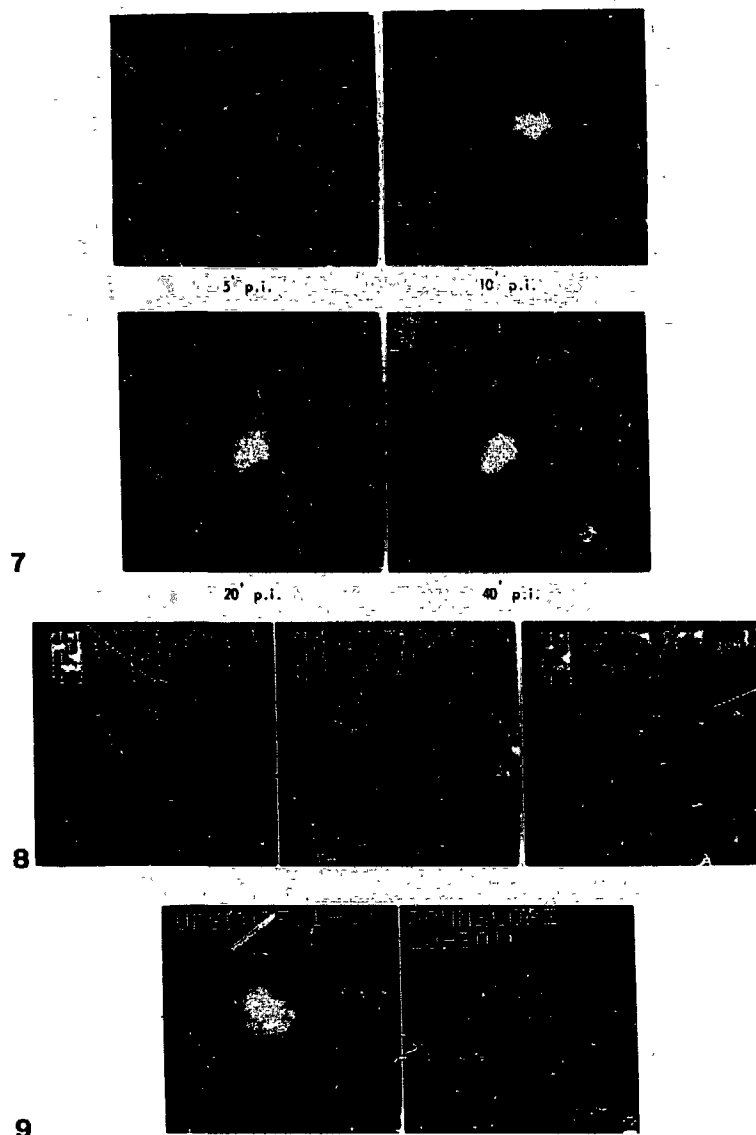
7-9 Cholescintigraphy in a patient with a drug induced hepatitis.
